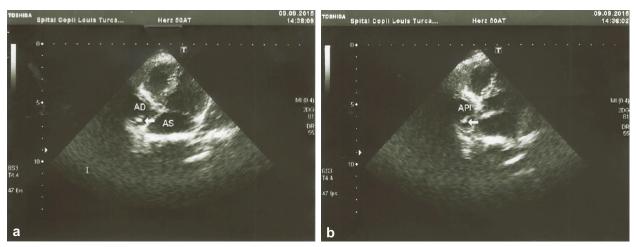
(a and b) Transthoracic cardiac ultrasound showed the presence of a hyperechogenic mass (0.5/2.73 cm) on the posterior wall of the right atrium, near the junction with the inferior vena cava (crista terminalis).
